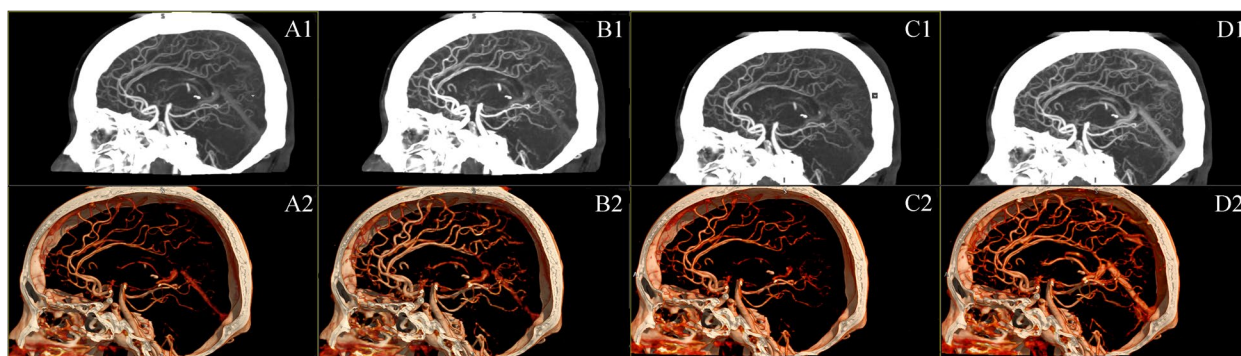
Example of qualitative assessment for image quality: A patient underwent a CTP scan, and the cerebral arteries were reconstructed from 4D CTA images to generate MIP and VR images. The MIP and VR images of CTA obtained from CTA_{peak} (A1, A2), CTA_{tMIP} (B1, B2), and CTA_{tAve} (C1, C3) were assigned a score of 4. Additionally, the MIP image of the CTA image derived from the CE-boost (D1, D2) received a score of 5 due to enhanced visualization of the distal second-order branches
